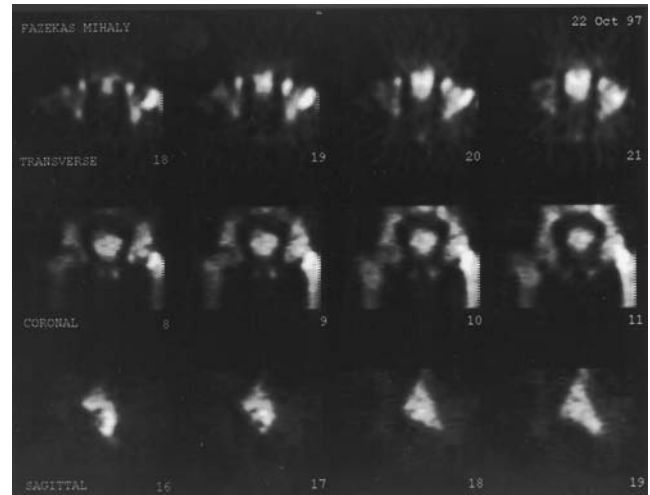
Clinical application of SPECT.
